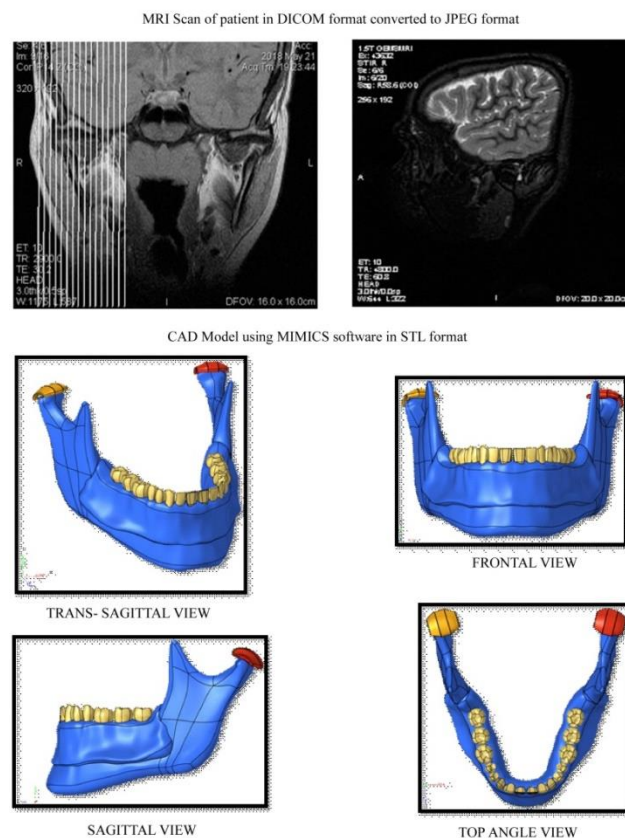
MRI Scan & CAD CAM Models
